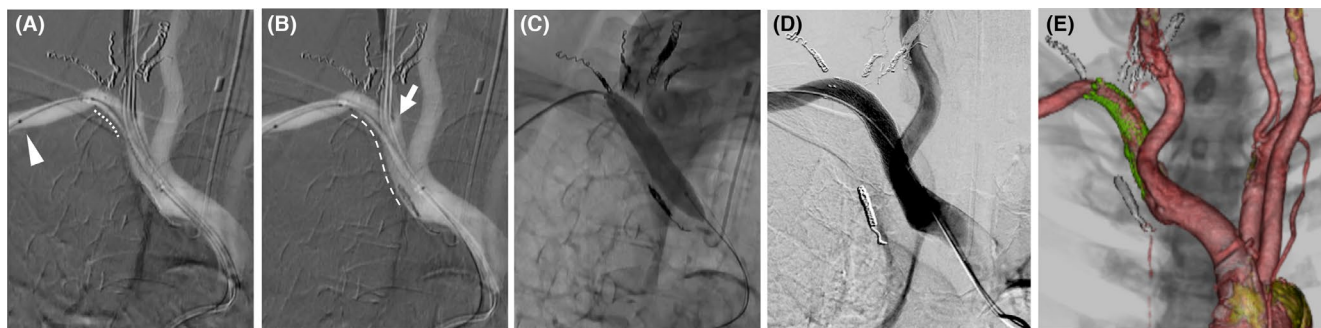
One-third stent deployment (dotted line) and positioning of a touch-up balloon distal to the stent (arrowhead pointing to the balloon tip) with the pull-through wire (A). Full deployment of the covered stent (dashed line) following catheter removal (B). Swift advancement and inflation of the balloon to secure the tear (C). The final angiography (D) and the follow-up computed tomography angiography (E) confirm successful repair.
